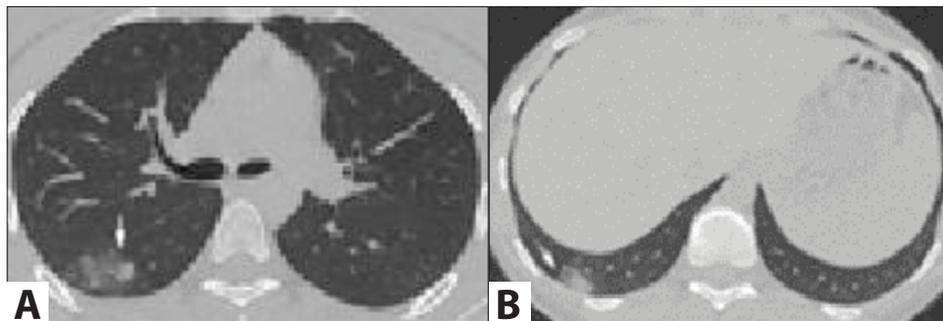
Sixteen-year-old female with Coronavirus disease, four days after symptom onset. (A) Axial CT image shows peripheral ground-glass opacities with consolidation in the right lower lobe, upper segment (arrow). (B) Axial CT image at the lower level displays a pulmonary nodule with peripheral ground-glass opacity (halo sign) in the right lower lobe, posterior basal segment.
